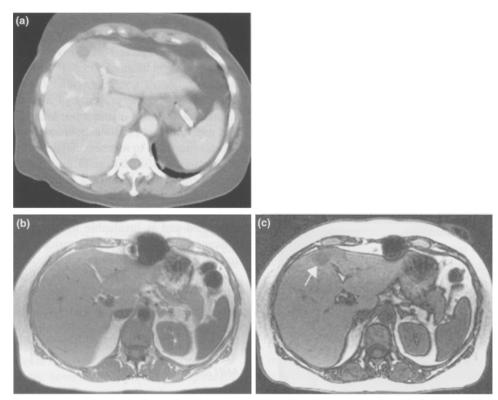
Focal fatty infiltration. (a) A low-density lesion is seen anteriorly in the liver; appearances are indistinguishable from a metastasis. (b) In-phase and (c) out-of-phase MRI was able to demonstrate that this was due to focal fatty infiltration. A fat-containing area within the liver will show a lowering in signal intensity on the out-of-phase images (arrow).
